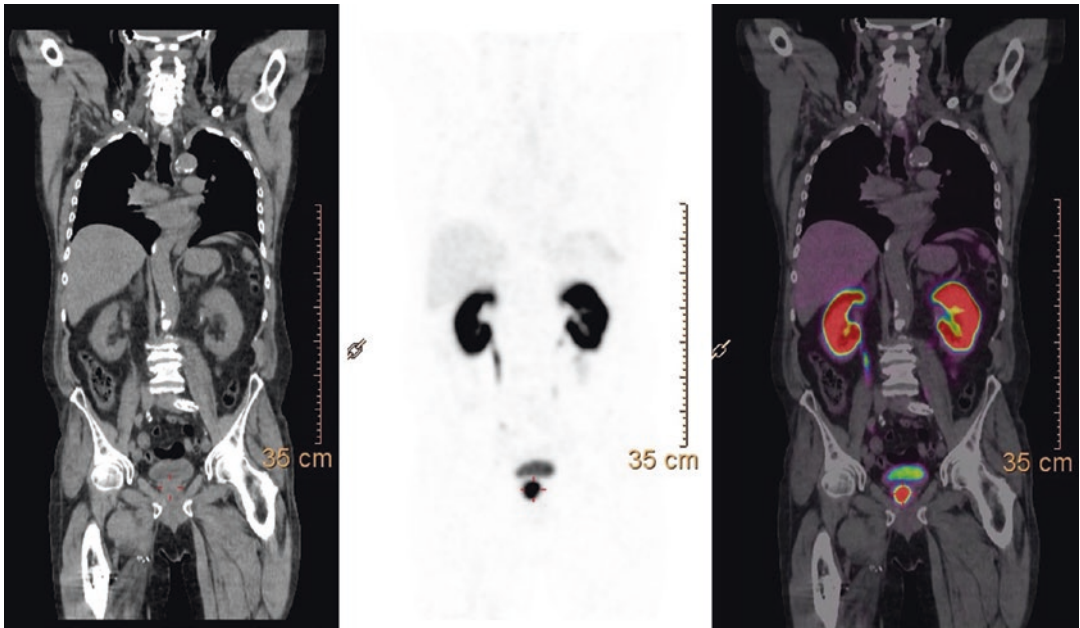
The images of this prostate cancer patient before prostatectomy show a marked uptake in the prostate primary. No metastases were observed by ⁶⁸Ga-PSMA PET/CT
